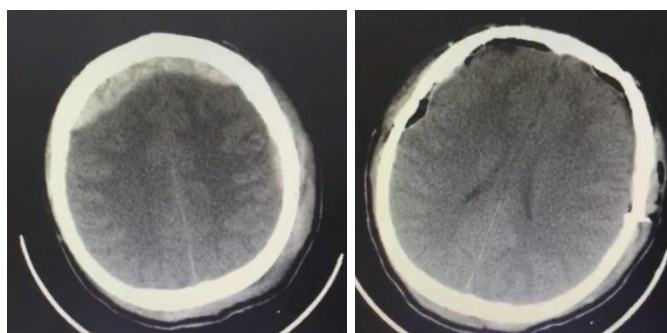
Pre and post-operative CT scan of Bifrontal Epidural Hematoma
